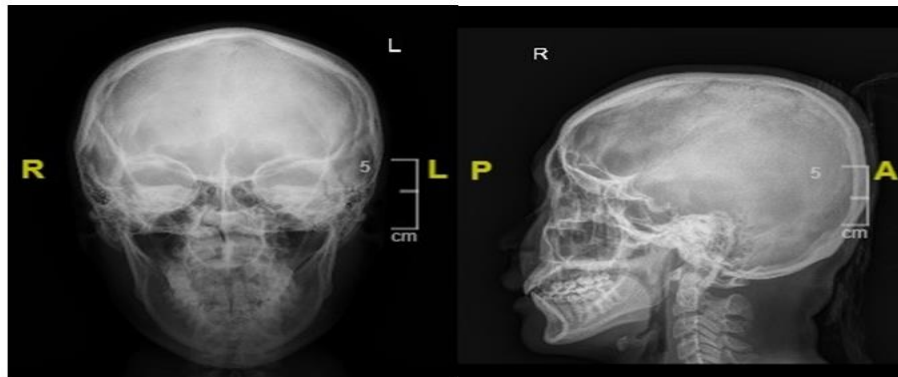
AP lateral skull radiographic appearance within normal limits
